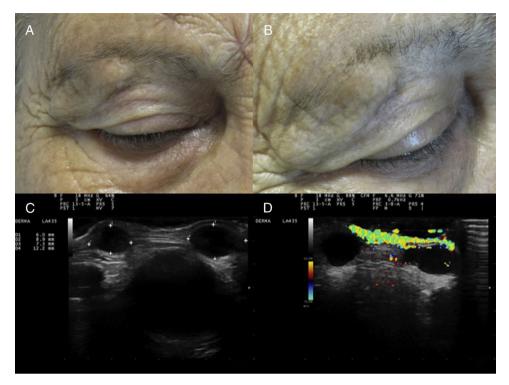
A and B, Two painless, skin-colored nodules of 1cm in diameter on the right eyebrow, showing no signs of associated phlogosis. C, B-mode skin ultrasound (18-MHz probe) showing 2 well-delimited, rounded, hypoechoic/anechoic subdermal structures with posterior reinforcement and lateral acoustic shadowing. D, Color Doppler skin ultrasound (18-MHz probe) showing increased perilesional flow.
